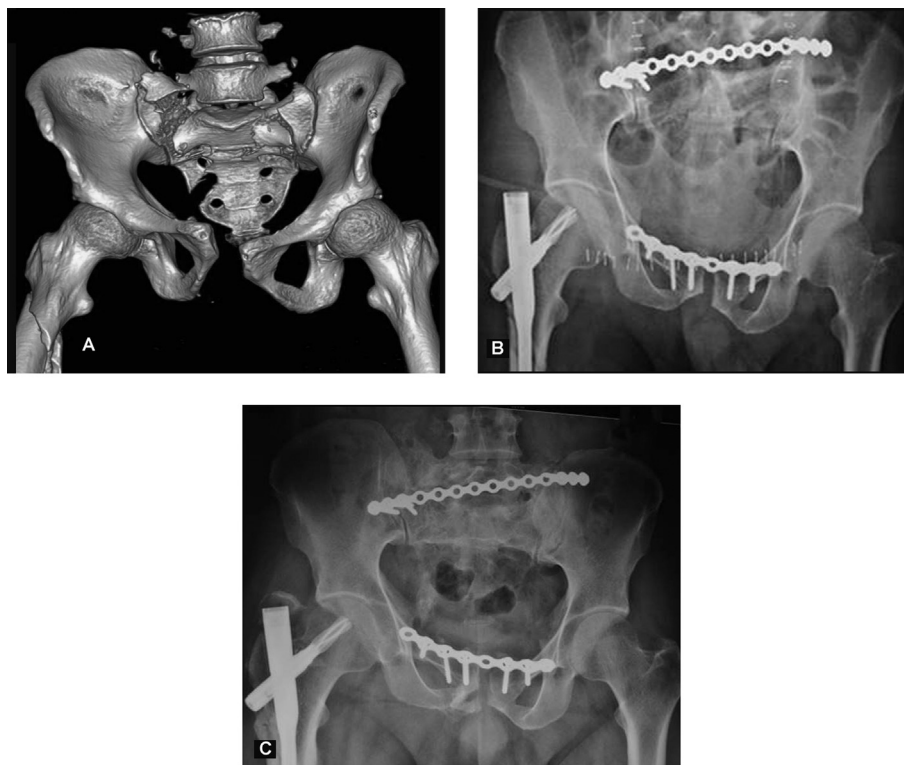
Management of a 23-year male, polytrauma with Tile pelvic injury type C1 and bilateral comminuted sacral fractures. (A) 3D reconstruction film of pelvis demonstrating the geometry of the fracture pattern in pelvis. (B) Post operative radiograph with the pelvis stabilized both anteriorly and posteriorly. (C) At 20 months follow up, sacral and pubic rami fractures are well united (Lindhal's grade A), without loss of reduction or any implant failures.
